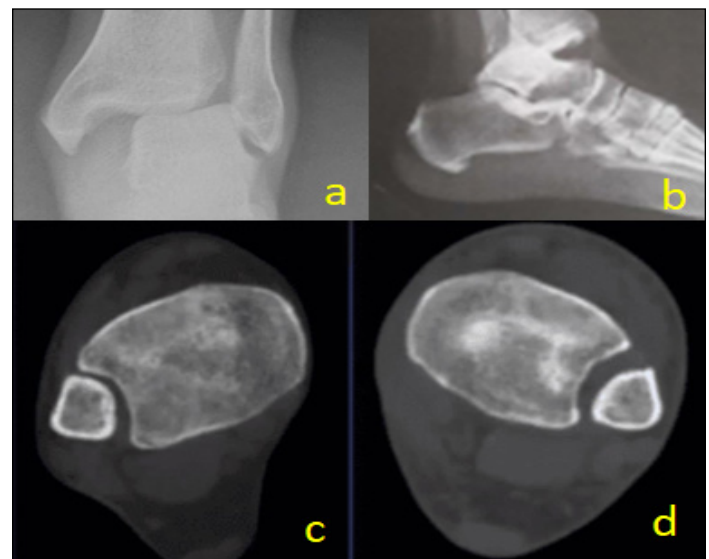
A-b: 44C3 ankle fracture with loss of fibular reduction in the fibular incisura. C-d: CT scan for comparison. The CT of the injured ankle was obtained after reduction in the Emergency Department.
